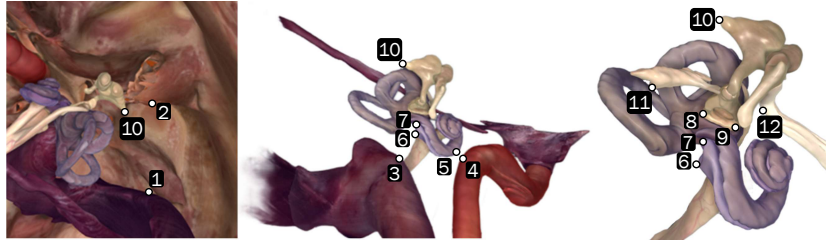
Set of landmarks annotated in normal anatomy CT images in the Real Abnormality Set. 1 - Sigmoid Sinus (SS) (closest point to EAC). 2 - External Acoustic Canal (EAC) (closest point to SS). 3 - Jugular Bulb (closest point to Round Window (RW)). 4 - Carotid Artery(CA) (closest point to Basal turn of the cochlea). 5 - Basal Turn (closest point to JB). 6,7 - Anterior and posterior edges of RW. 8,9 - Anterior and posterior crus of staples. 10 - Short Process of Incus. 11 - Pyramidal Process 12- Cochleariform Process. Edited from [18].
